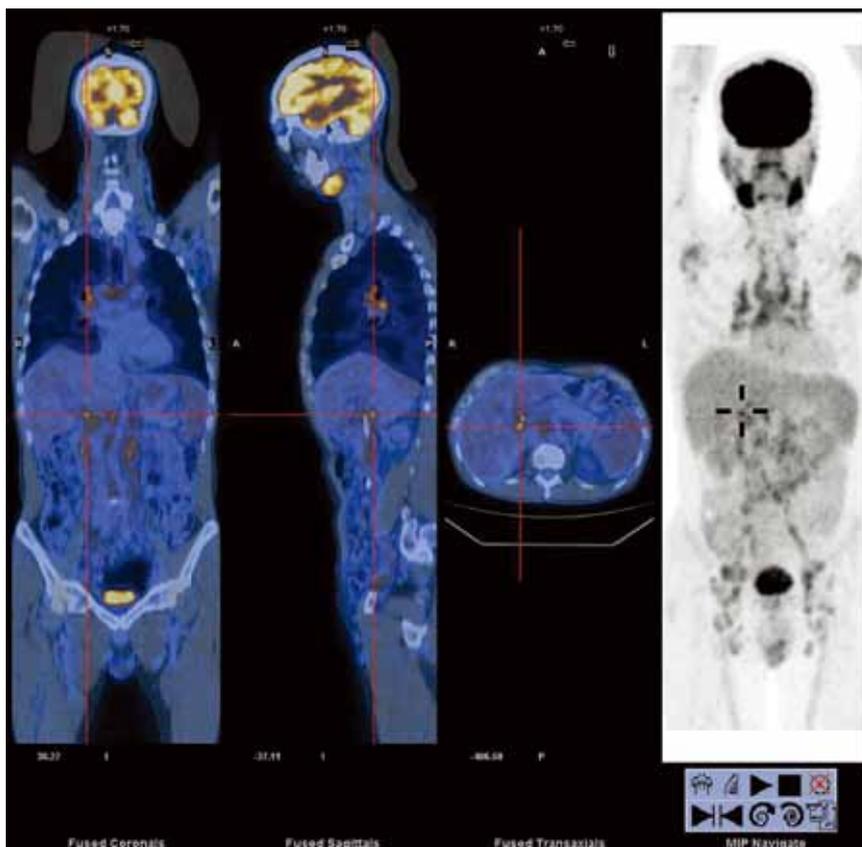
Positron emission tomography–computed tomography shows diffuse supra- and infra-diaphragmatic lymphadenopathy, including an enlarged porta-hepatis lymph node with a maximum standardised uptake value of 6.1.
